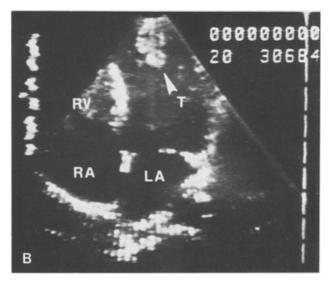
Two-dimensional echocardiogram in the four-chamber view of a left ventricular thrombus. A normal, B thrombus.
